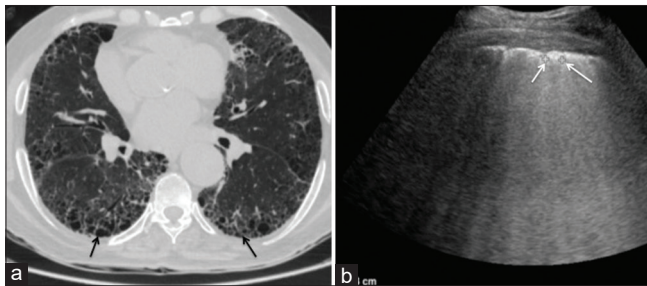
(a) Axial computed tomography image of a patient with idiopathic pulmonary fibrosis showing areas of honeycombing (black arrows) and reticulations (b) Corresponding ultrasonographic image performed using convex probe shows multiple B-lines. The distance between B-lines is wider, i.e., 7.1 mm (white arrows)
